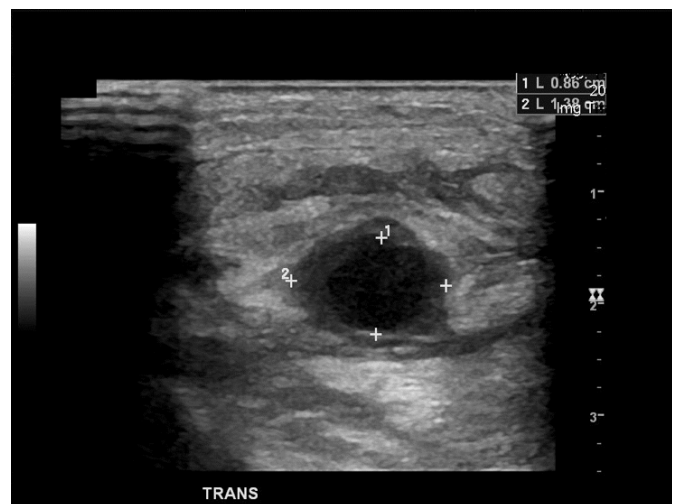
Axial plane ultrasound depicting radial artery fusiform aneurysm.
